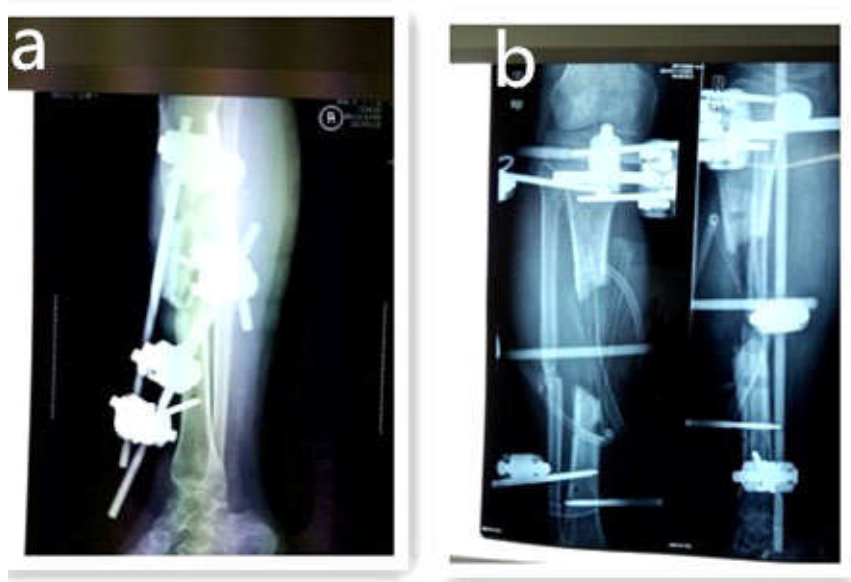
A 23 year old male patient with a comminuted fracture of the tibia, a. The radiograph 1 month after the fracture b. The radiograph, after clearance of the necrotic bone
